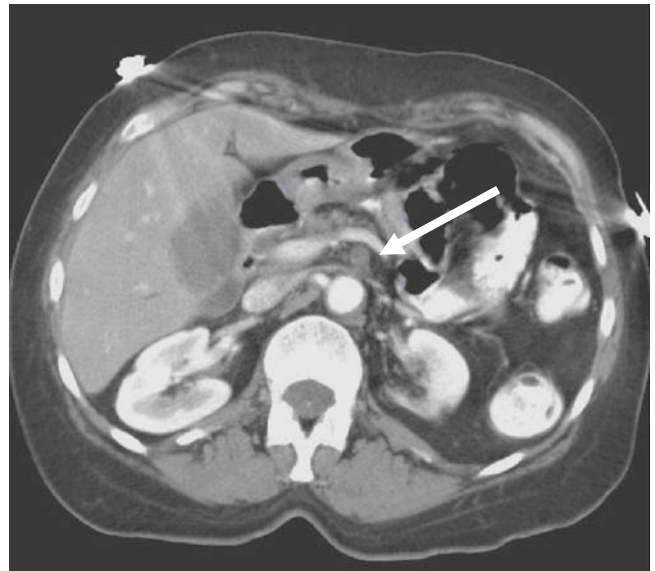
CT scan of superior mesenteric artery (SMA) thrombosis at the origin of the vessel. This is usually due to underlying atherosclerosis. Emboli lodge at the origin of the SMA in about 30% or fewer of cases.
